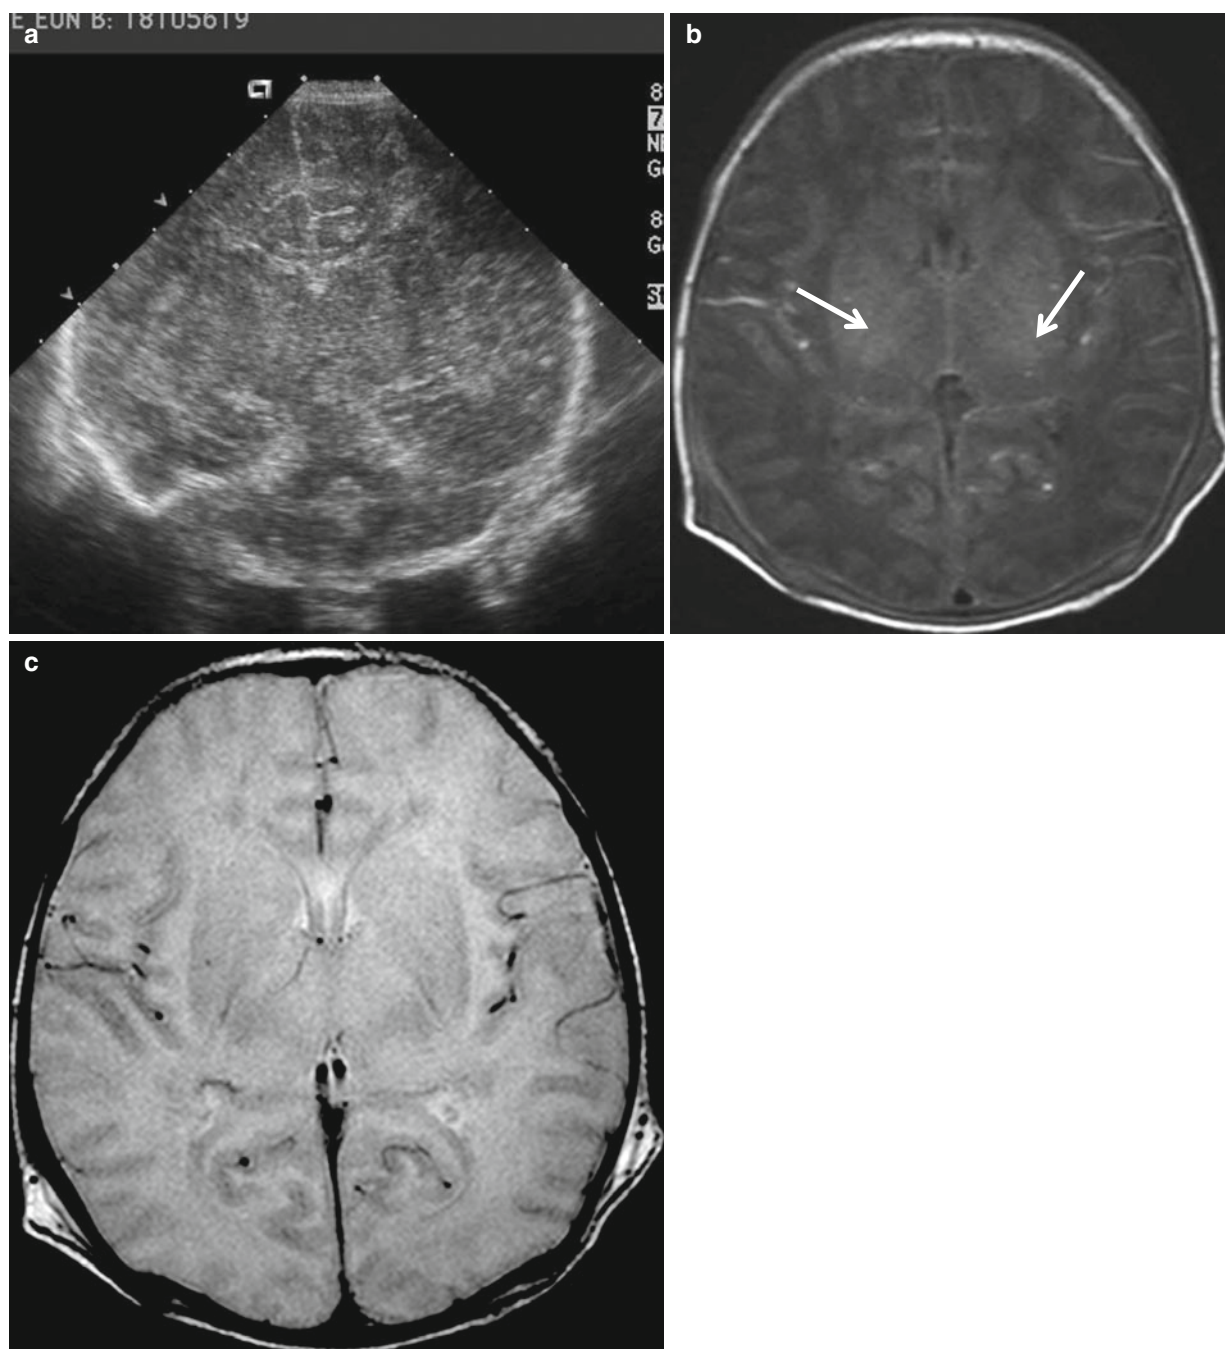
Term neonate with meconium aspiration. (a) Sonography shows diffusely edematous brain and subtle echogenic thalami. (b, c) Normal posterior internal capsule myelin is absent on fast inversion recovery T1- and T2-weighted images (arrow), referred to as “absent
